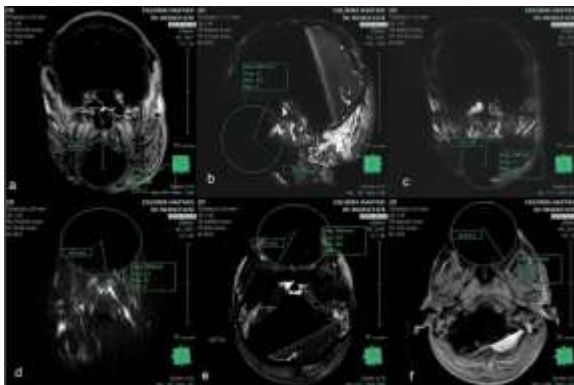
Artifact measurements of steel brackets. a, T₁ coronal plane; b, 3D flair sagittal plane; c, T₂ coronal plane; d, DWI axial plane; e, T₂ axial plane; f, T₁ axial plane
